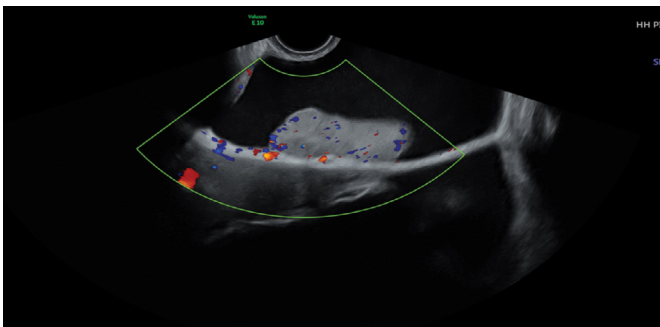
Color Doppler Ultrasound reveals minimal blood flow.
